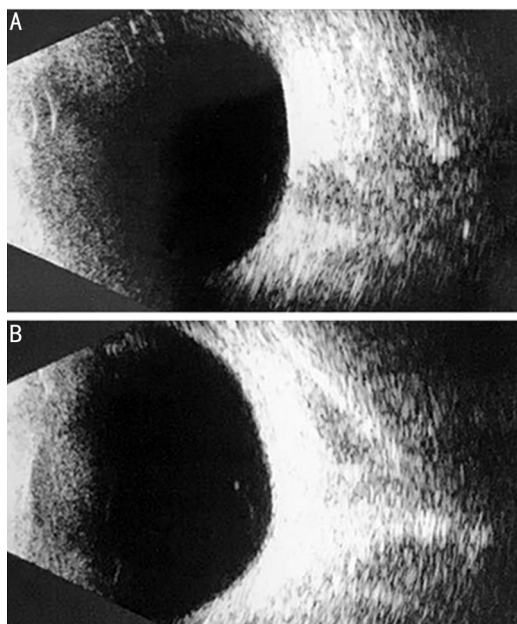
B-scan ultrasonography for both eyes A: Right eye; B: Left eye. It revealed binocular mild vitreous opacity.
